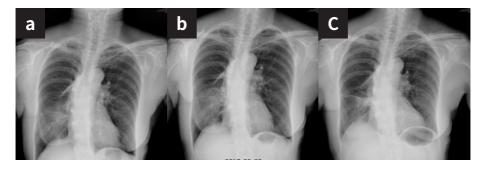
Chest radiography (04-25-2017, 05-03-2017, and 05-31-2017). After two cycles of pembrolizumab, the clinical symptoms and images were improved.
